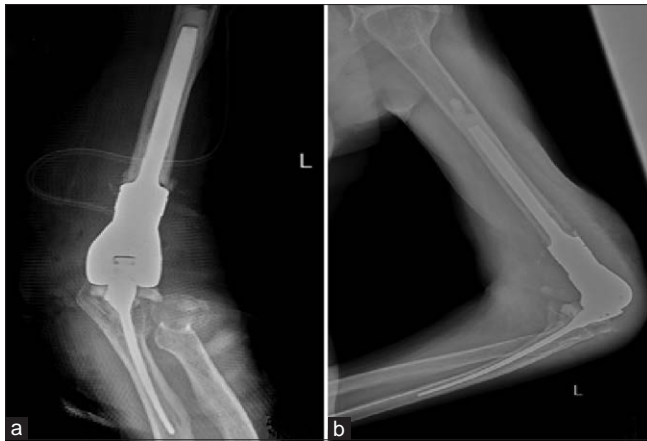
Postoperative plain radiograph showing elbow megaprosthesis. (a) Anteroposterior view; (b) Lateral view
